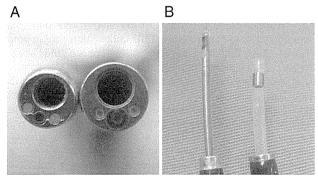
A comparison of bronchoscopes. *A,* Tip of the 3.4-mm thin bronchoscope with a 1.7-mm working channel (*left*) and the 4.0-mm bronchoscope with a 2.0-mm working channel (*right*). *B,* A 3.4-mm bronchoscope with a 1.4-mm ultrasonic probe (*left*) and a 4.0-mm bronchoscope with a guide sheath which is compatible with the 1.4-mm ultrasonic probe (*right*).
